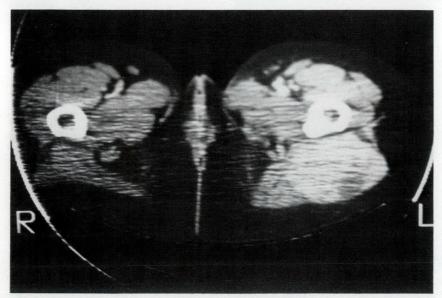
Computed tomogram demonstrated lesion of left thigh compressing sciatic nerve.
